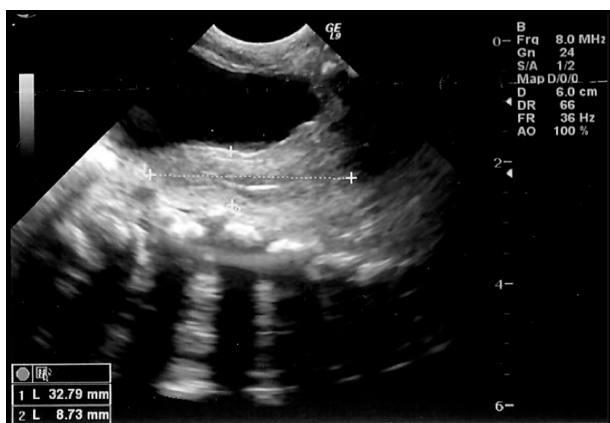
Pelvic ultrasound.
